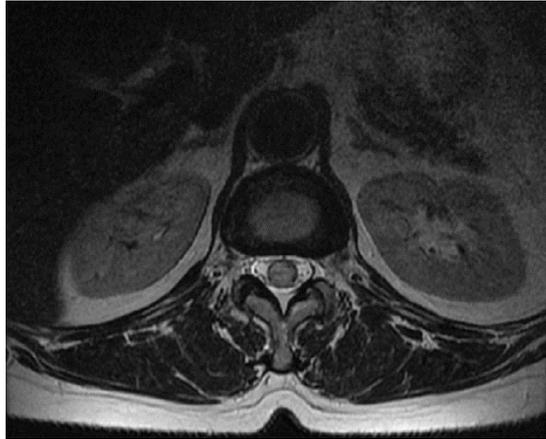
MRI image showing intraspinal metastasis of breast cancer to the spinal cord-axial view
